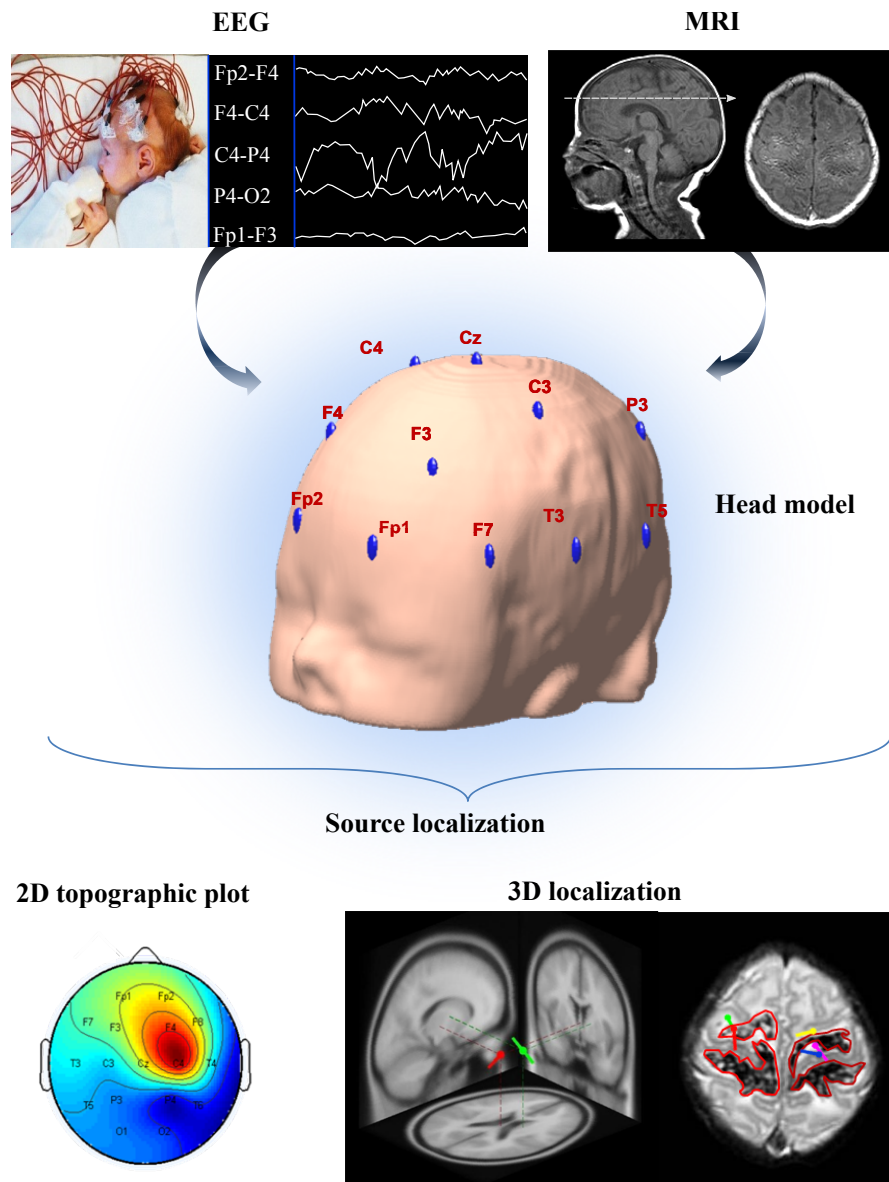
Overview of a multimodal brain analysis integrating EEG and MRI data for 3D dipole source localization in neonates.
